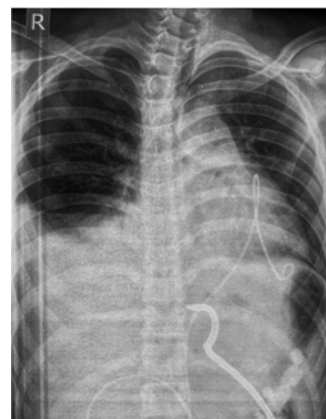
X-ray chest with upper abdomen showing pericardial and hepatic pigtail catheters.
